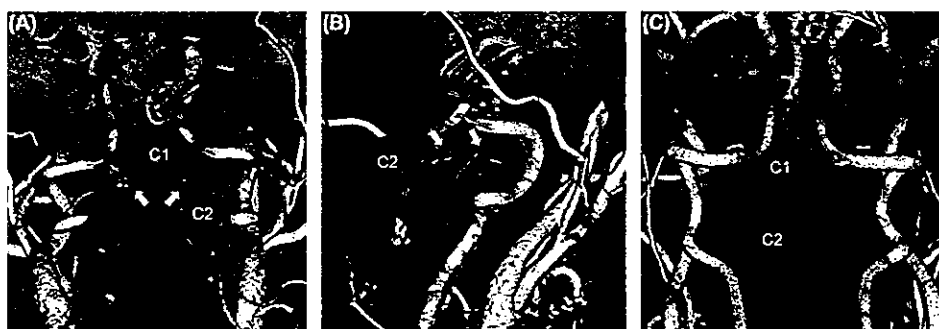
Poor arterial blood supply of the odontoid process in patients with an atraumatic odontoid fracture. Examples of three-dimensional CT angiography images in the posterior–anterior view (A) and oblique view (B) depicting anterior and posterior ascending arteries of the odontoid process (white arrows) in a patient with early RA. Three-dimensional CT angiogram of Patient 2 showing no ascending arteries of the odontoid process (C). Ascending arteries of the odontoid process were not observed in any patients of this series on CT angiography.
